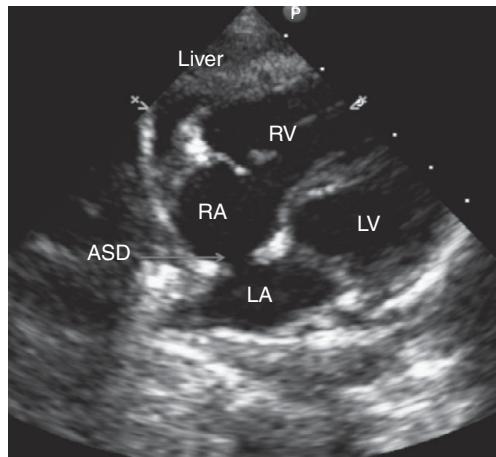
Left: Subcostal transthoracic echocardiography demonstrating a secundum type ASD. Right: Cardiac catheterization pictorial of a patient with a moderate ASD. There is a “step up” in saturation from the superior vena cava (76%) to the right atrium (88%).
